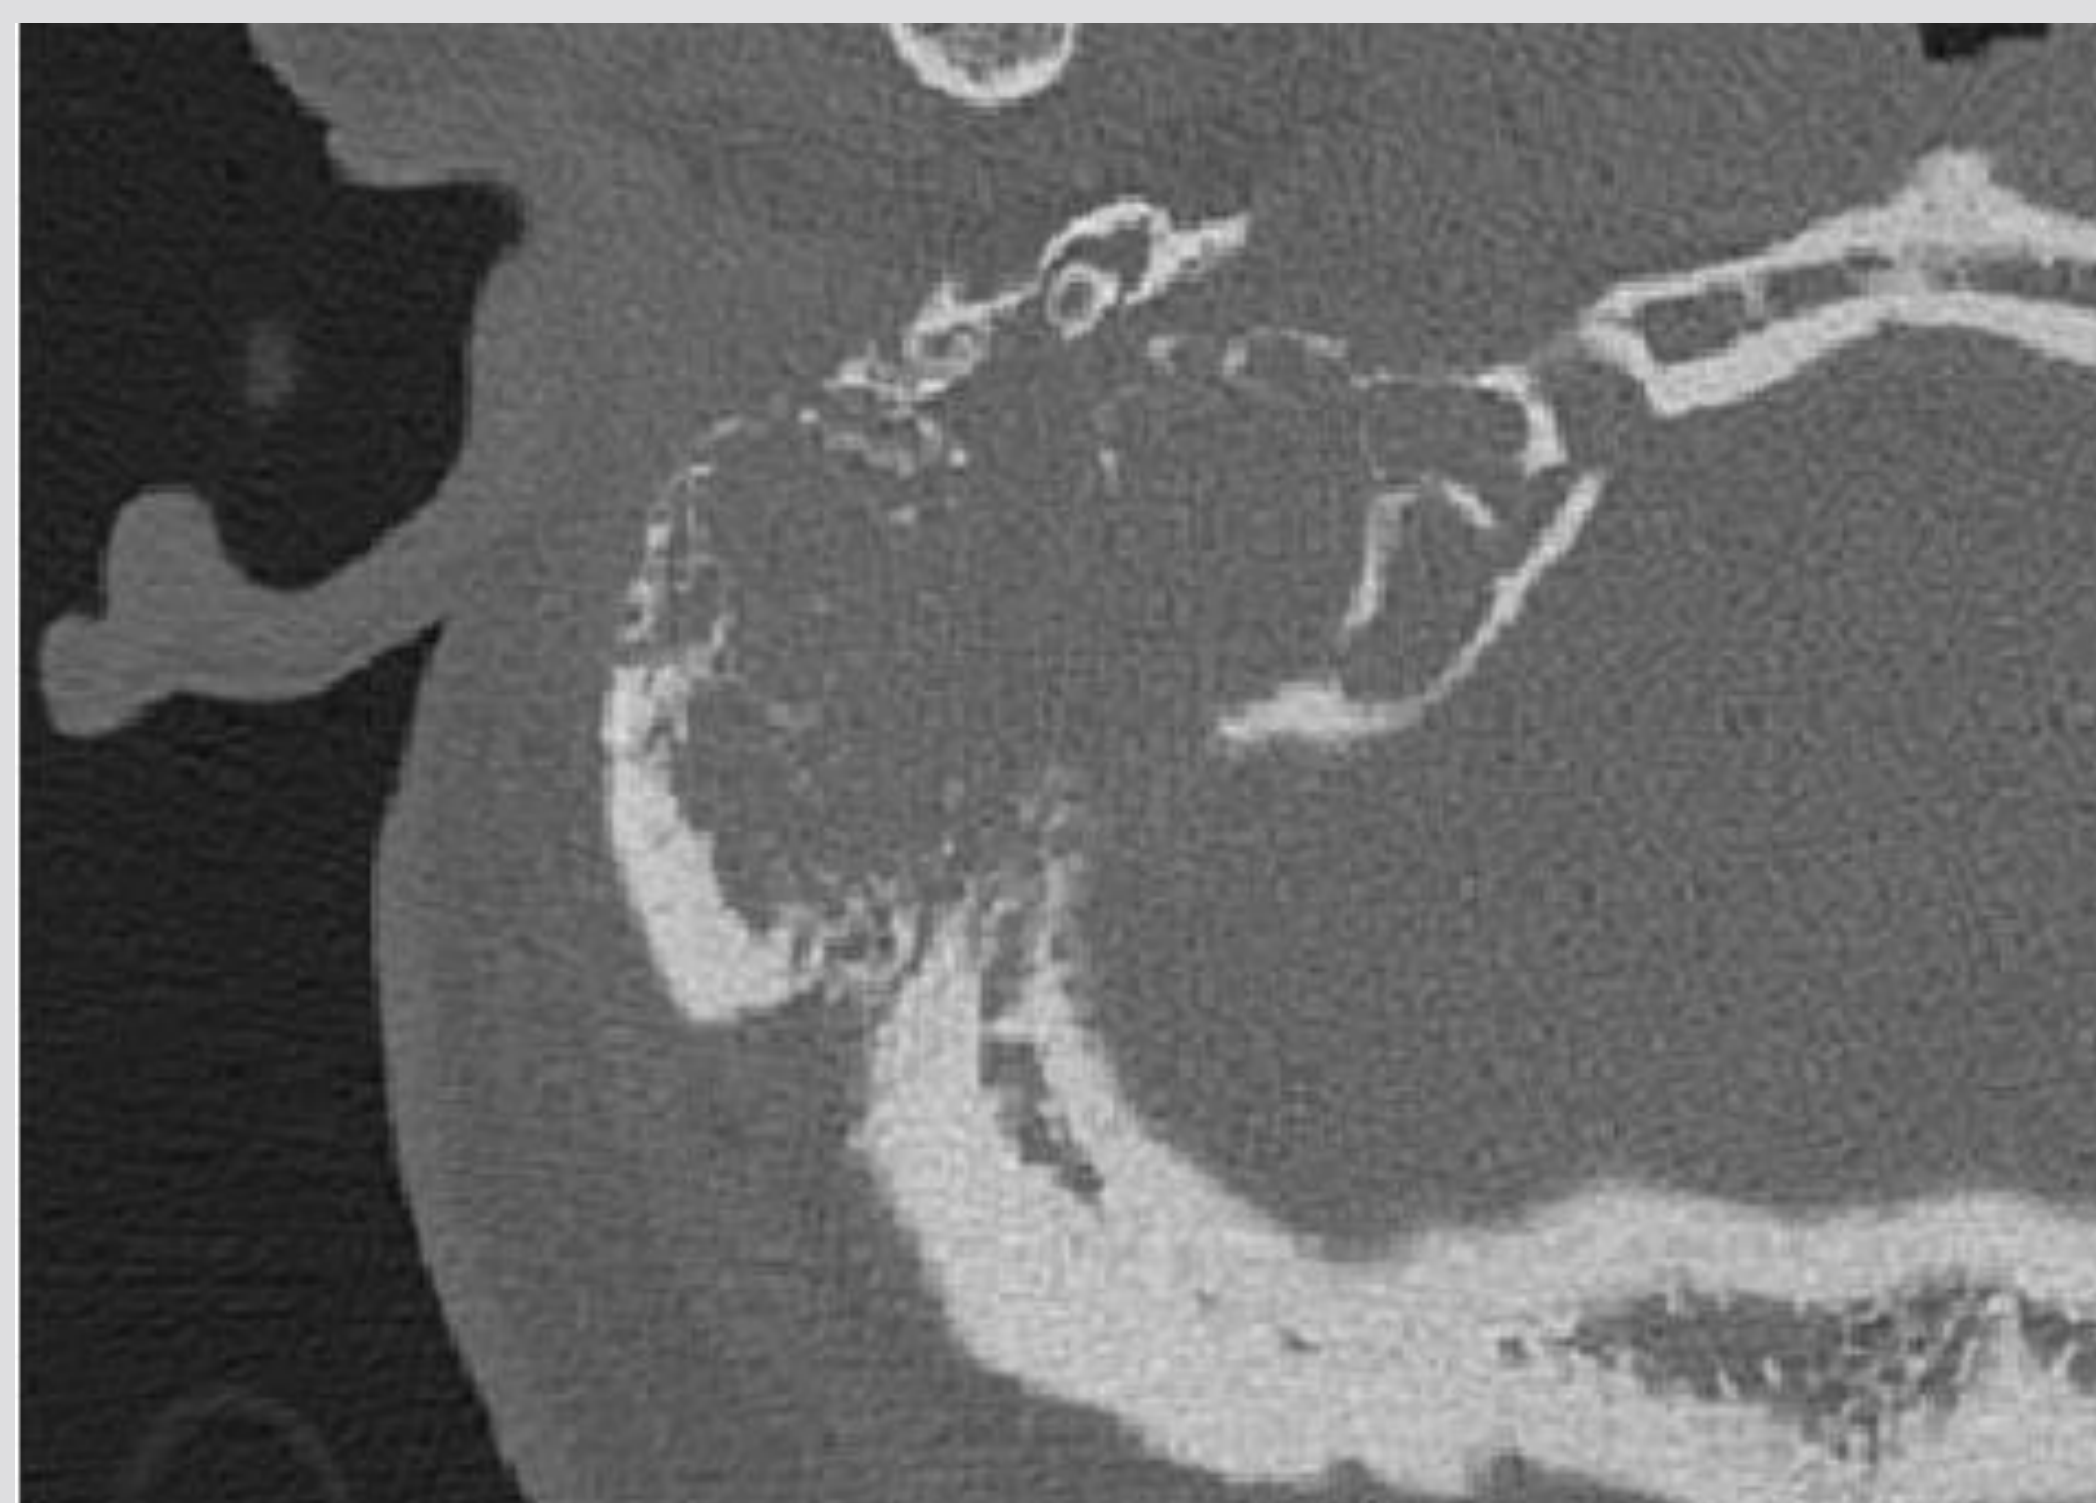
Representative axial CT scan image from initial presentation.
